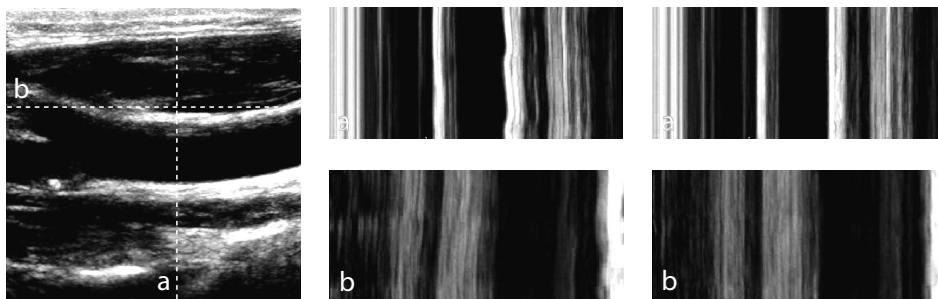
Registration result for a 2D+t ultrasound image of the carotid artery. Left and middle: input image, right: registration result. Image (a) and (b) show the dotted lines in the left image over time.
